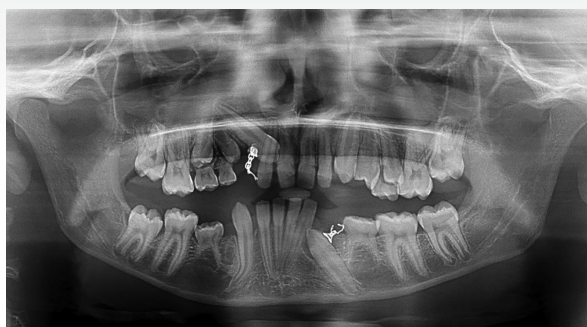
Panoramic X-Ray, preoperative, initial presentation.
